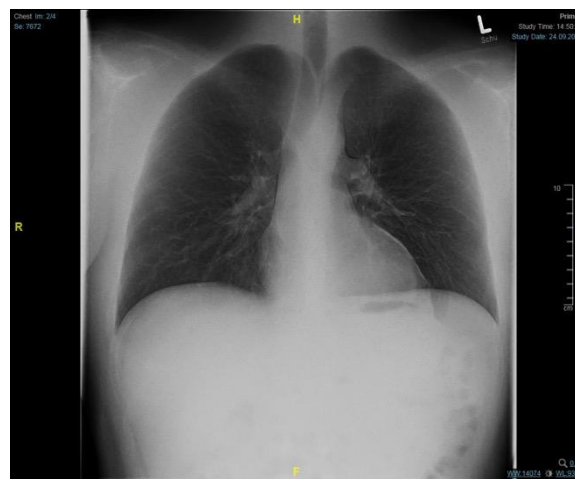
Chest X-ray with atypical pneumonia-like features
